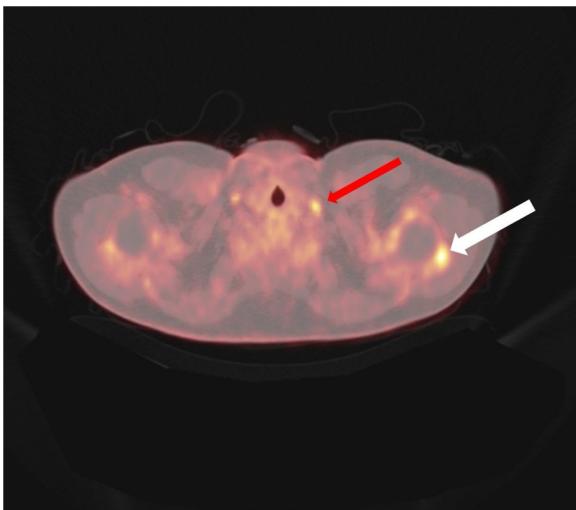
PET-CT showing metabolically activity at COVID injection site (white arrow) and a left supraclavicular fossa node with SUV 5 (red arrow). Activity was also found in a small lymph node in the right supraclavicular fossa.
